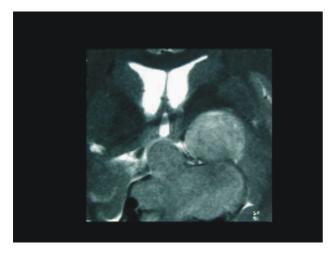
Post-contrast T1-weighted sagittal MR image showing Grade I giant pituitary tumor with a sub-frontal extension. B. Post-contrast post-operative T1-weighted coronal MR image showing complete excision of the tumor including the sub-frontal extension.
